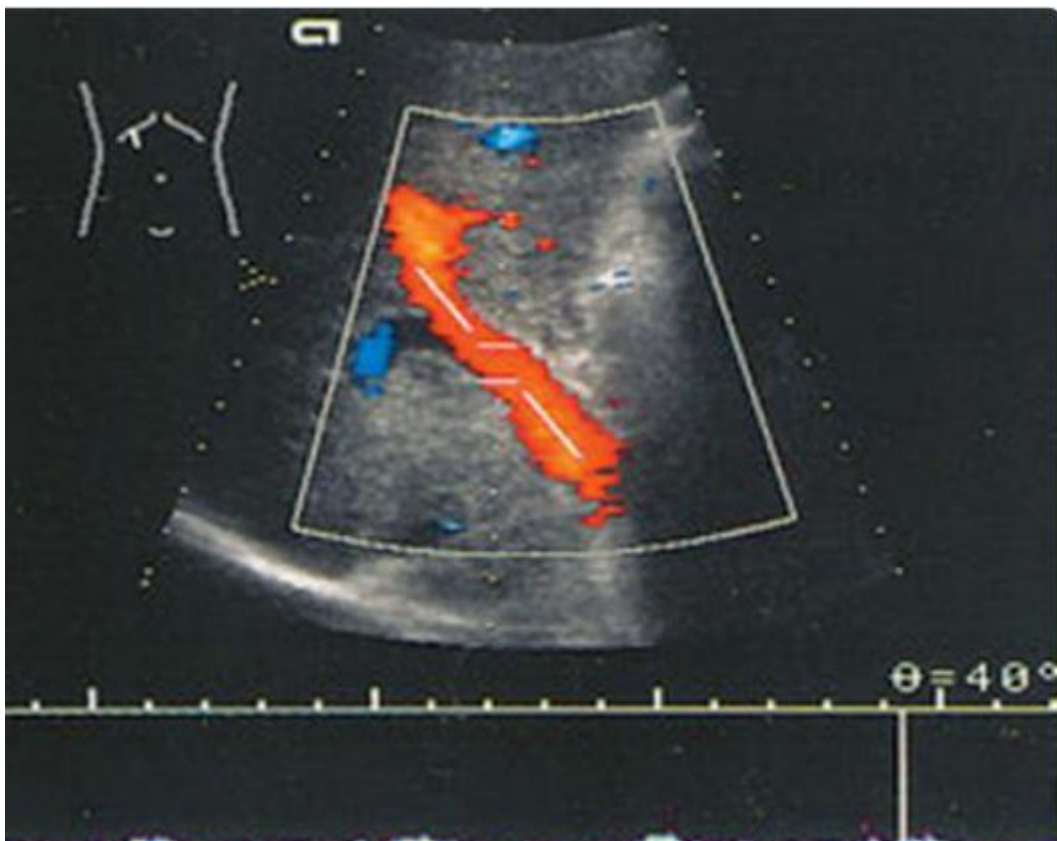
sub costal sonographic feature of Portal hypertension, (www.startradiology.com 2016) W.D.M Middleton et al.
